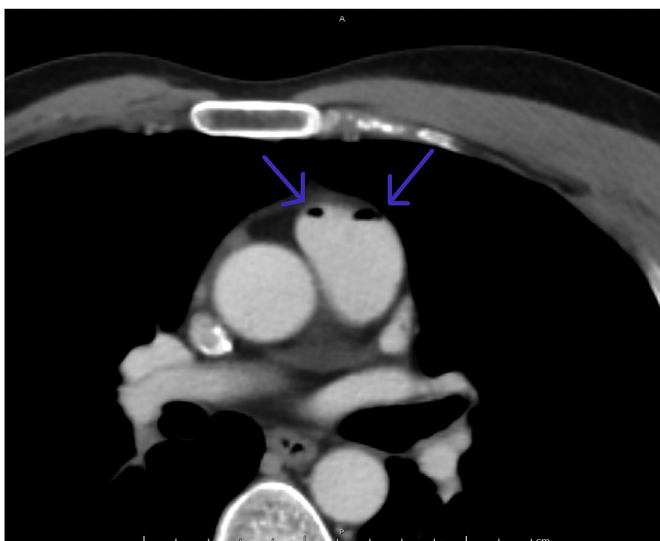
Axial contrast-enhanced chest computed tomography image showing in the main pulmonary artery air bubbles (arrows).
